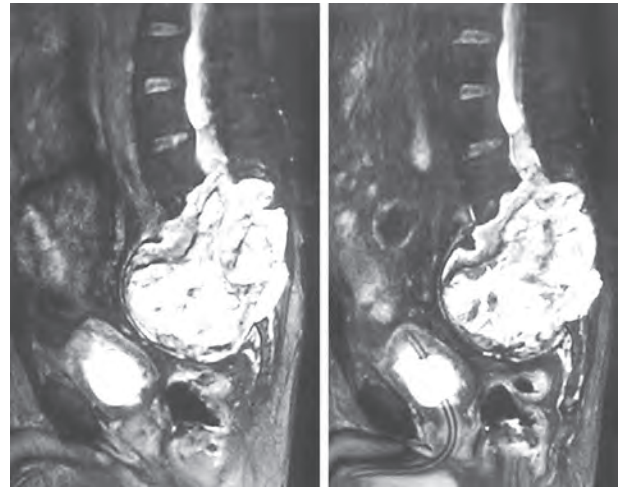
MRI (T2-weighted) lumbosacral spine showing giant ependymoma
